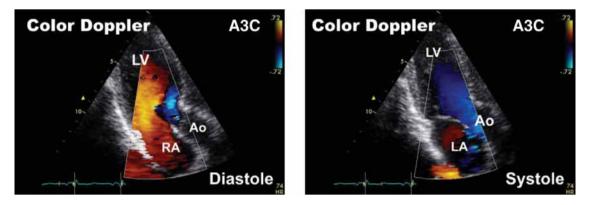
Apical long-axis or apical three-chamber (A3C) view. (See companion DVD.)
